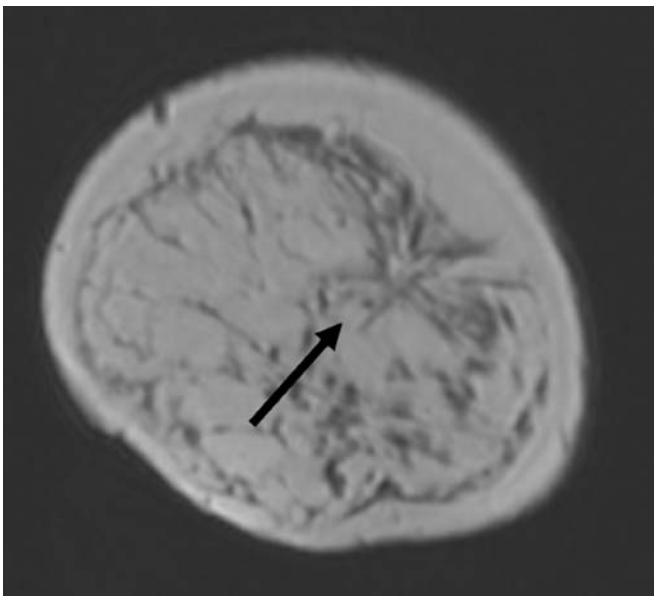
Radial sclerosing lesions. a) FLASH T1 non-enhanced MRI image demonstrates an area of architectural distortion in the upper-outer quadrant of the left breast (arrow). Stereotactically-guided vacuum-assisted biopsy diagnosis was radial sclerosing lesion and it was confirmed at surgical excision.
